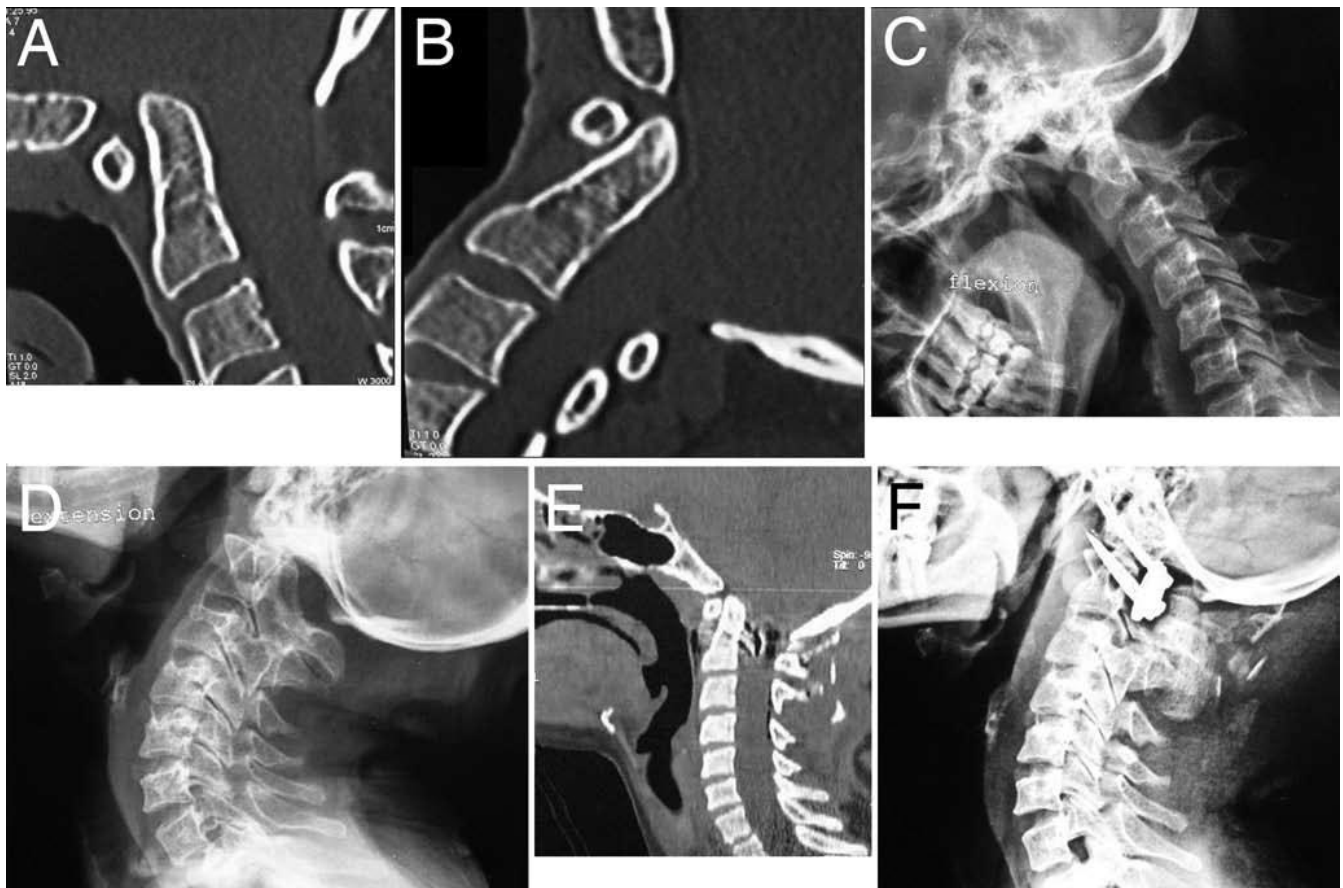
Neuroimages obtained in a 54-year-old woman with unstable basilar invagination. A: Sagittal CT scan reconstruction with head in flexion, showing vertical dislocation (or basilar invagination). B: Sagittal CT scan obtained with the head in extension, showing reduction of the dislocation. C: Radiograph of the craniovertebral junction with the head in flexion, showing evidence of basilar invagination and atlantoaxial dislocation. D: Radiograph obtained with the head in extension, showing reduction of the dislocation. E: Postoperative CT scan showing fixation of the atlantoaxial dislocation in reduced position. F: Postoperative radiograph showing fixation with plate and screws.
